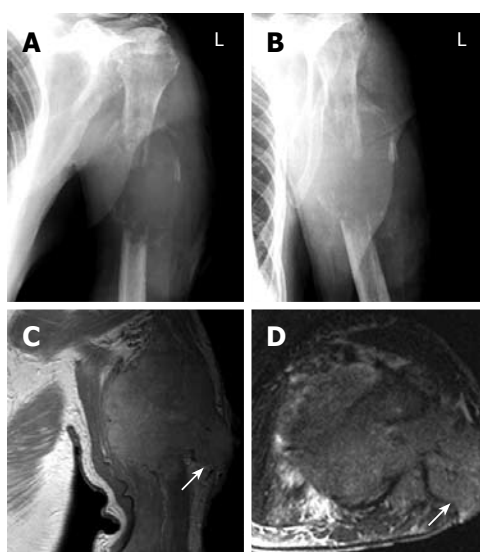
X-Ray (A, B) and MR imaging (C, D) of HCC metastasis at the humerus. A and B: Destructive lesion in the left humerus associated with a bulging soft tissue component, 5.5 cm × 4 cm in dimension; C: Coronal noncontrast PD-weighted (TR/TE, 1920/12) image demonstrating a soft tissue tumor (coronal dimension 6.2 cm × 5 cm) with complete destruction of the humerus, the tumor reached the surface with ulceration (arrow); D: Axial noncontrast TIRM sequences (TR/TE, 7400/92) show the edematous tumor in the centre of the extremity and the lateral tumor branch to the surface (arrow). In this region, a biopsy was taken which was followed by massive hemorrhage.
